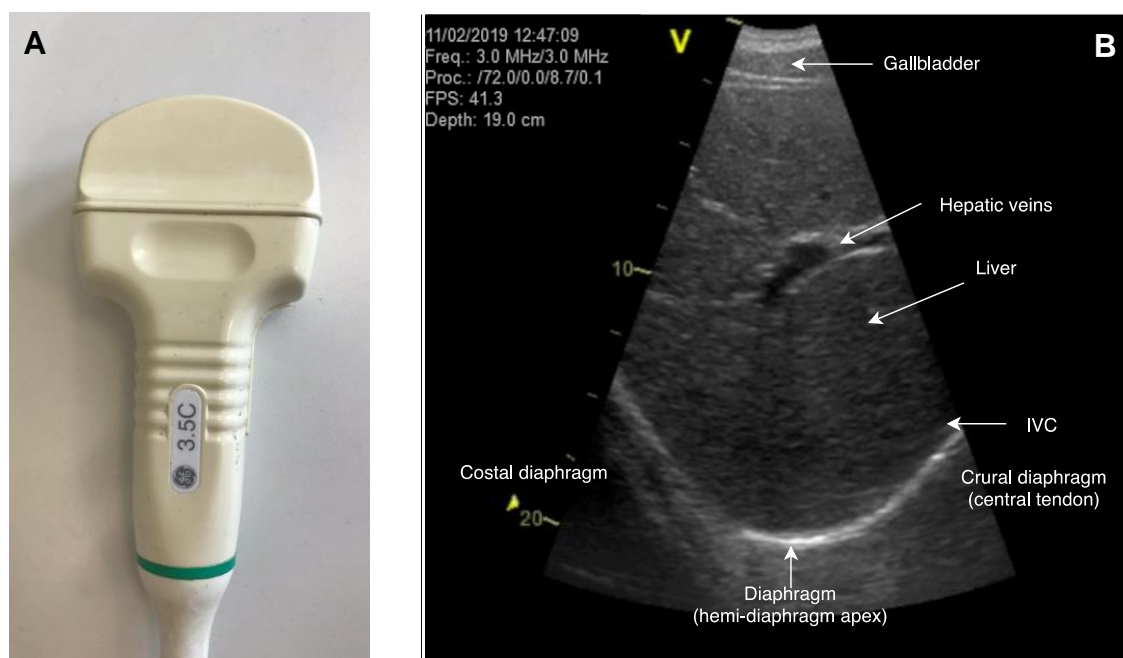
A) Curvilinear transducer to assess crural diaphragm excursion during spontaneous breathing. B) B-mode ultrasound of crural diaphragm with curvilinear transducer. IVC was readily identified in all subjects due to pulsating motion (not visible on still-image). In this example, crural diaphragm was imaged in the same female participant as above.
